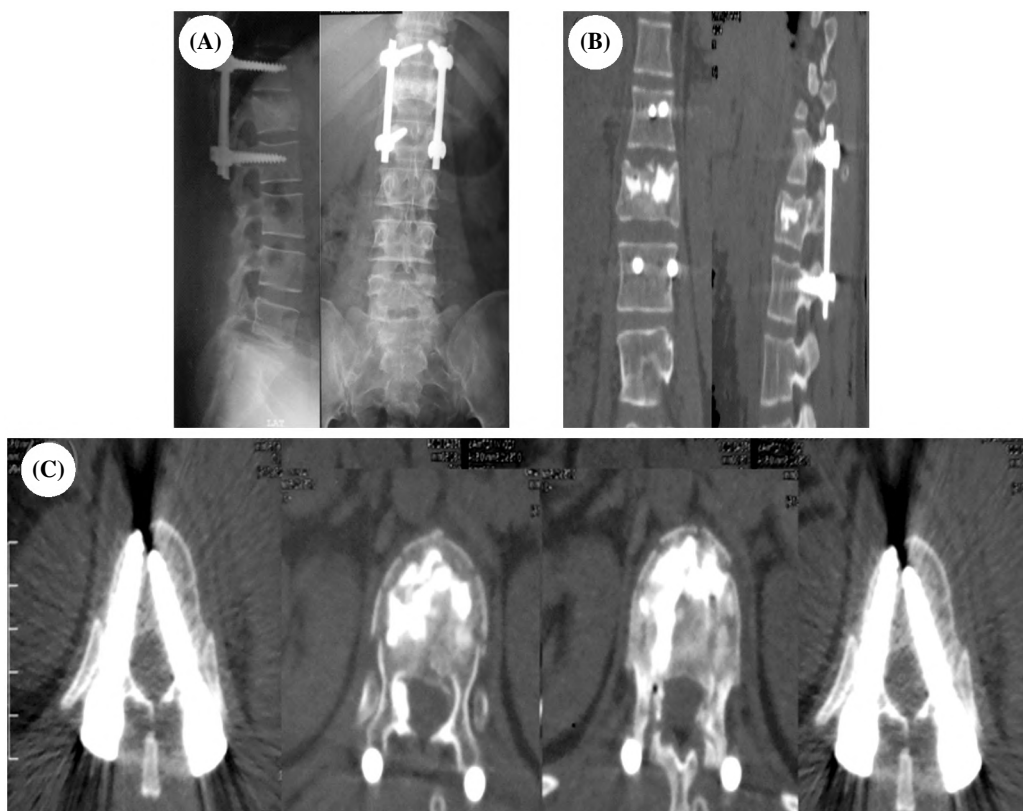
(A) Post-operative X-ray, (B) Post-operative coronal, sagittal CT scan & (C) Post-operative axial CT scan showing reduction of kyphotic angle to 3 degrees and appearance of radio-opaque GeneX with clearance of spinal canal. The right pedicular screws penetrate the medial pedicular cortex without neurological problems.
